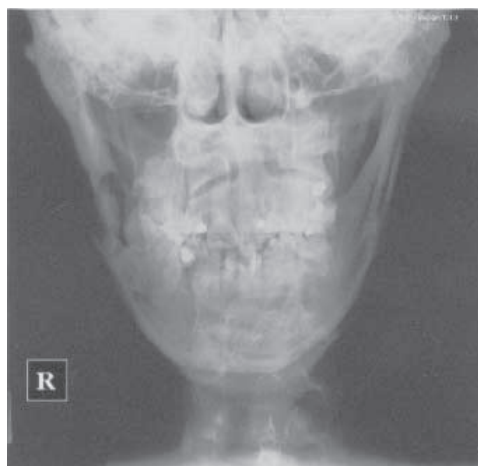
Frontal radiograph of the mandible.
